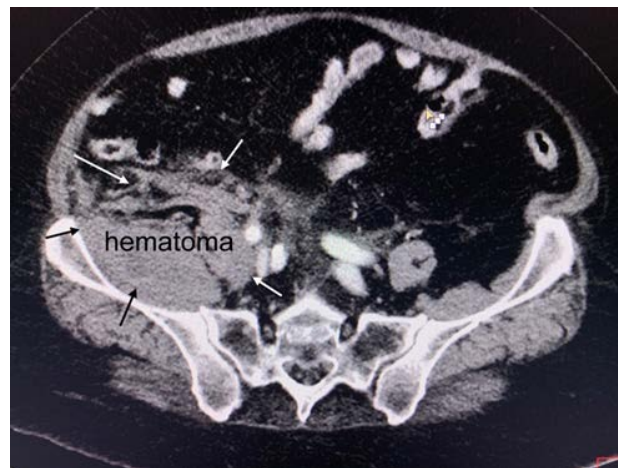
CT scan (without intravenous contrasting) of the right iliopsoas muscle hematoma. The thickening and heaviness of the structure of m. Iliopsoas, pronounced the imbibition of her blood.
